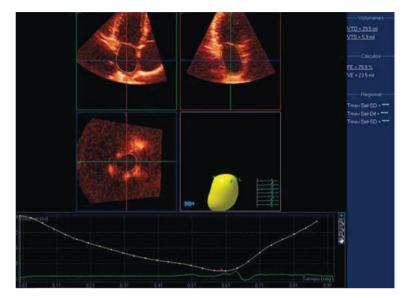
Measurement of left atrial volume using RT3D echocardiography
